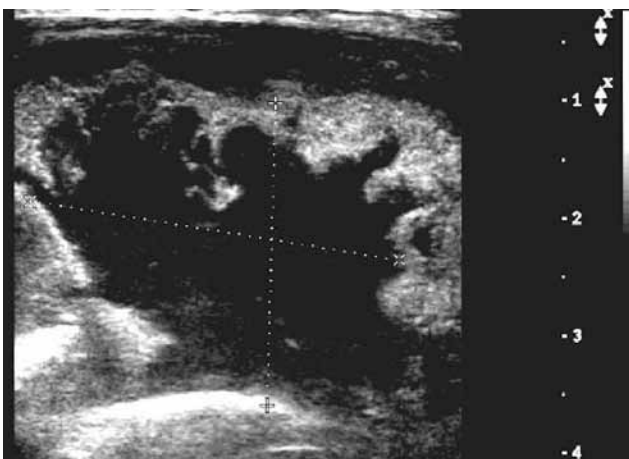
Ultrasound shows fluid-filled mass in left groin region.
